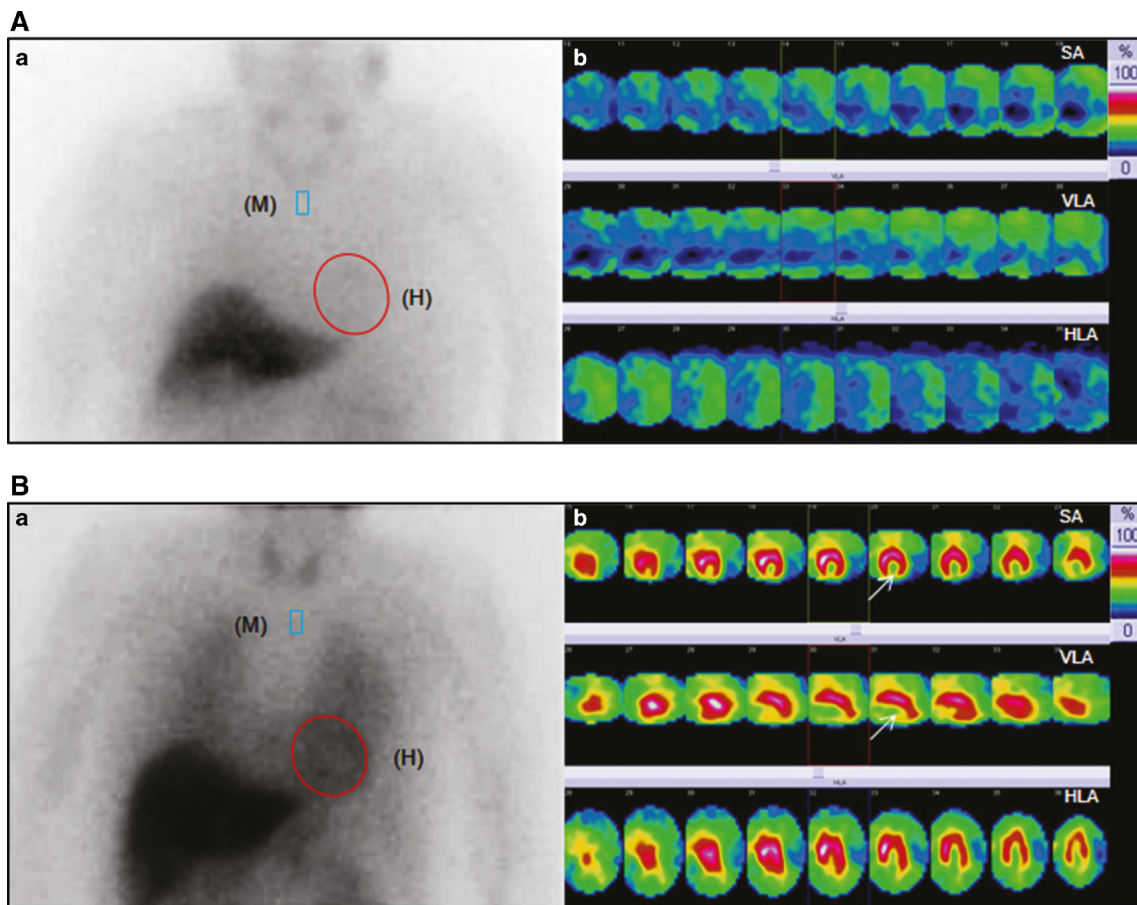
a A 68-year-old patient referred for a parkinsonian syndrome with visual hallucinations and cognitive disorders. a Planar ¹²³I-MIBG anterior view of the thorax showed a drastic decrease of the HMR (1.09). b ¹²³I-MIBG SPECT showed a complete myocardial denervation with an IDS of 68/68. The final clinical diagnosis was dementia with Lewy bodies. HMR delayed heart to mediastinum ratio, IDS innervation defect score, SA short axis, VLA vertical long axis, HLA horizontal long axis, (H) heart, (M) mediastinum
